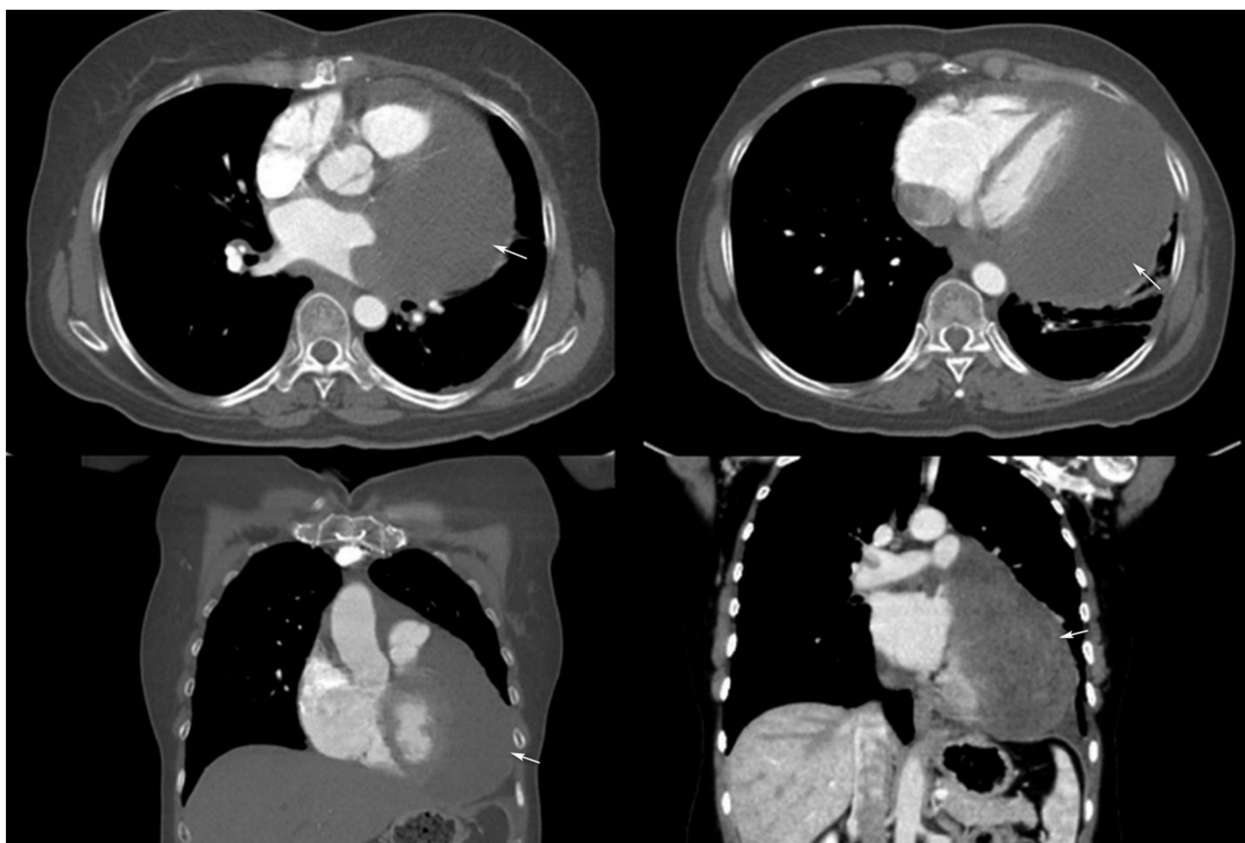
At 18 months, a follow-up CT with contrast enhancement—axial (upper images) and coronal (lower images) plane reveals a homogeneous tumor relapse near the left heart border (arrows), invading the left atrium, right superior pulmonary vein and periaortic root.
